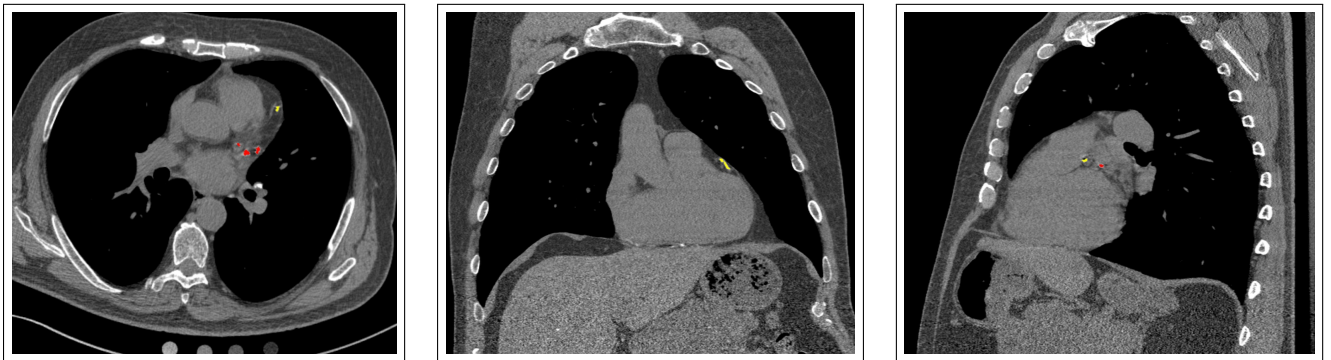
Example images of the RGB overlay series shown in the axial, coronal, and sagittal (L to R) orientations. The gray scale original CT image is overlaid with the coronary calcifications detected by the software and color-coded according to the coronary artery.
